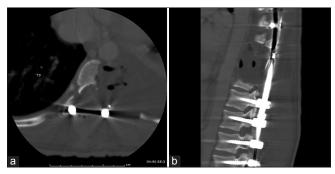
Postoperative noncontrast computed tomographic scan in both axial (a) and sagittal (b) dimensions showing gross total resection of the osteochondroma
